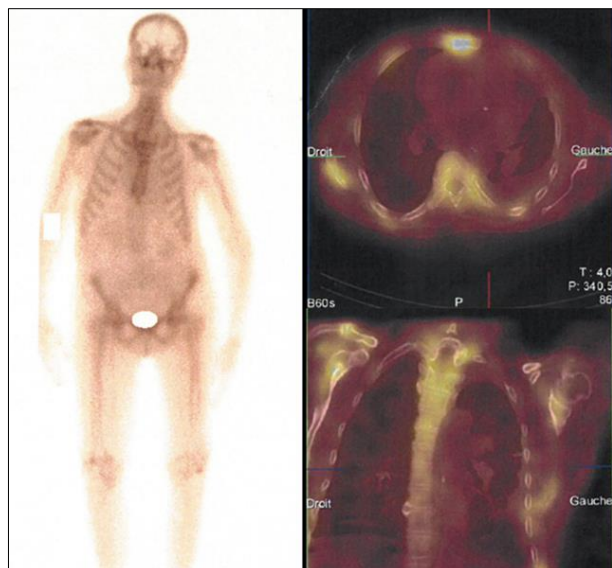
nuclear scintigraphy and SPECT showing the absence of myocardial uptake of the radiotracer Tc 99th HMDP
